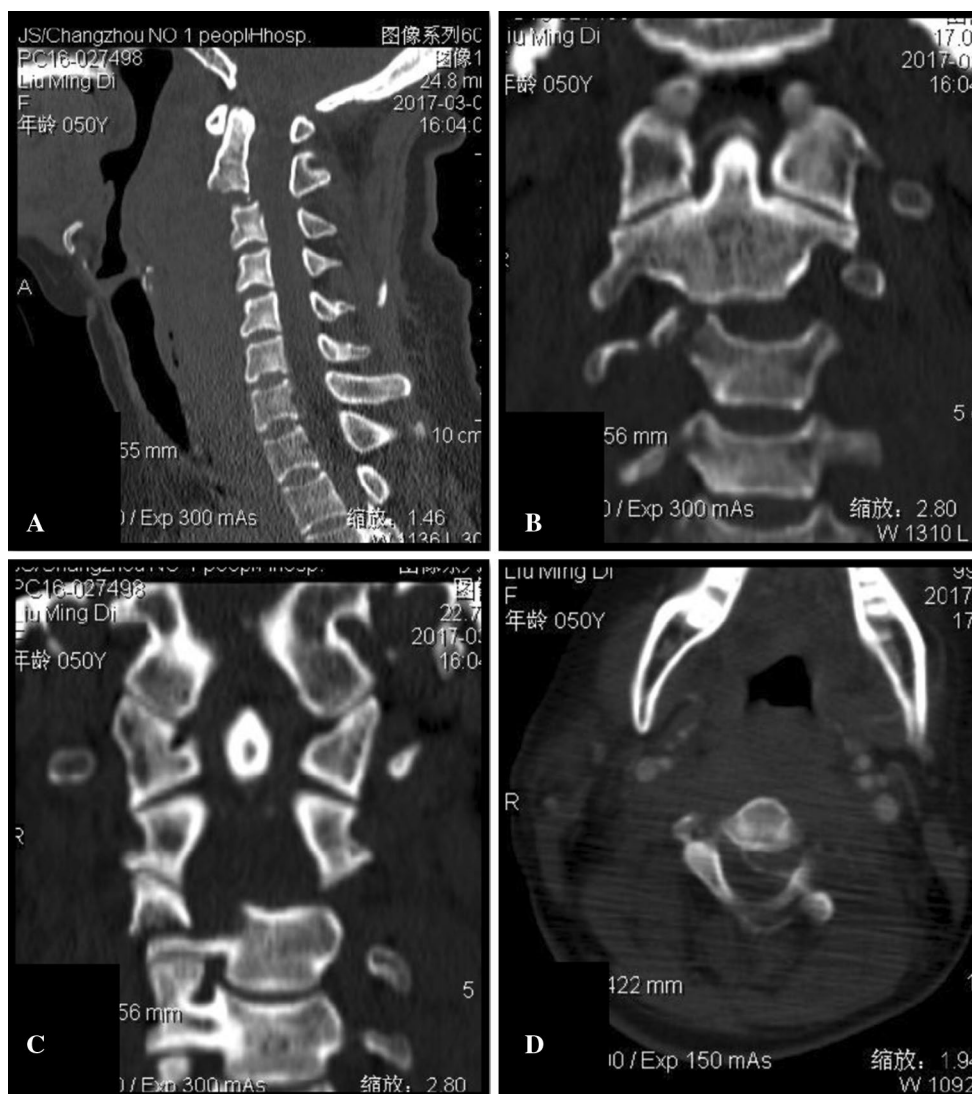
Sagittal 3D reformatted cervical CT (a–d) showing a dislocated fracture at C2–C3 with interspinous process widening, which was clearly unstable, a rotational anterolisthesis of C2–C3 in CT combined with a facet joint, and a transverse foramen fracture on the left side
